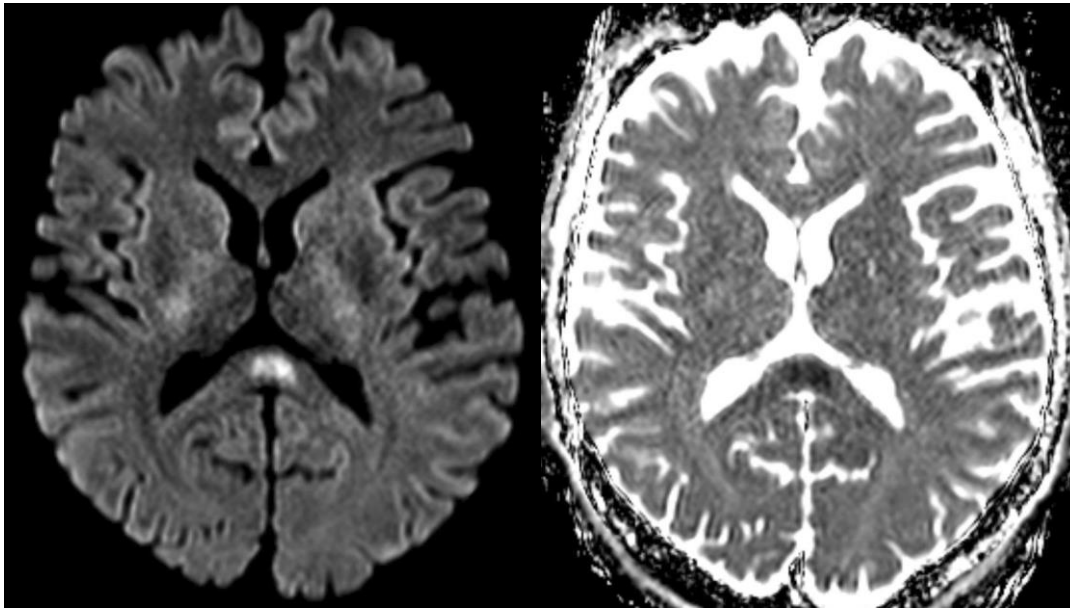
Brain MRI axial diffusion-weighted image ( $b = 1000 \text{ s/mm}^2$ ) (left) shows a high signal intensity in the splenium of corpus callosum. Apparent diffusion coefficient (ADC) map image (right) shows a low ADC. This image was originally published with a CC BY licence (27).
